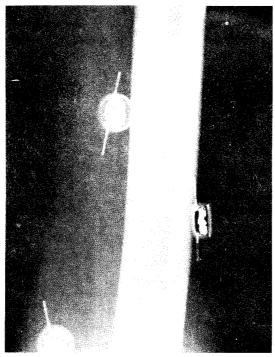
X-ray Picture of three distinctly coded 8-Channel Stimulators implanted within the Extensor-Muscles of the Knee
